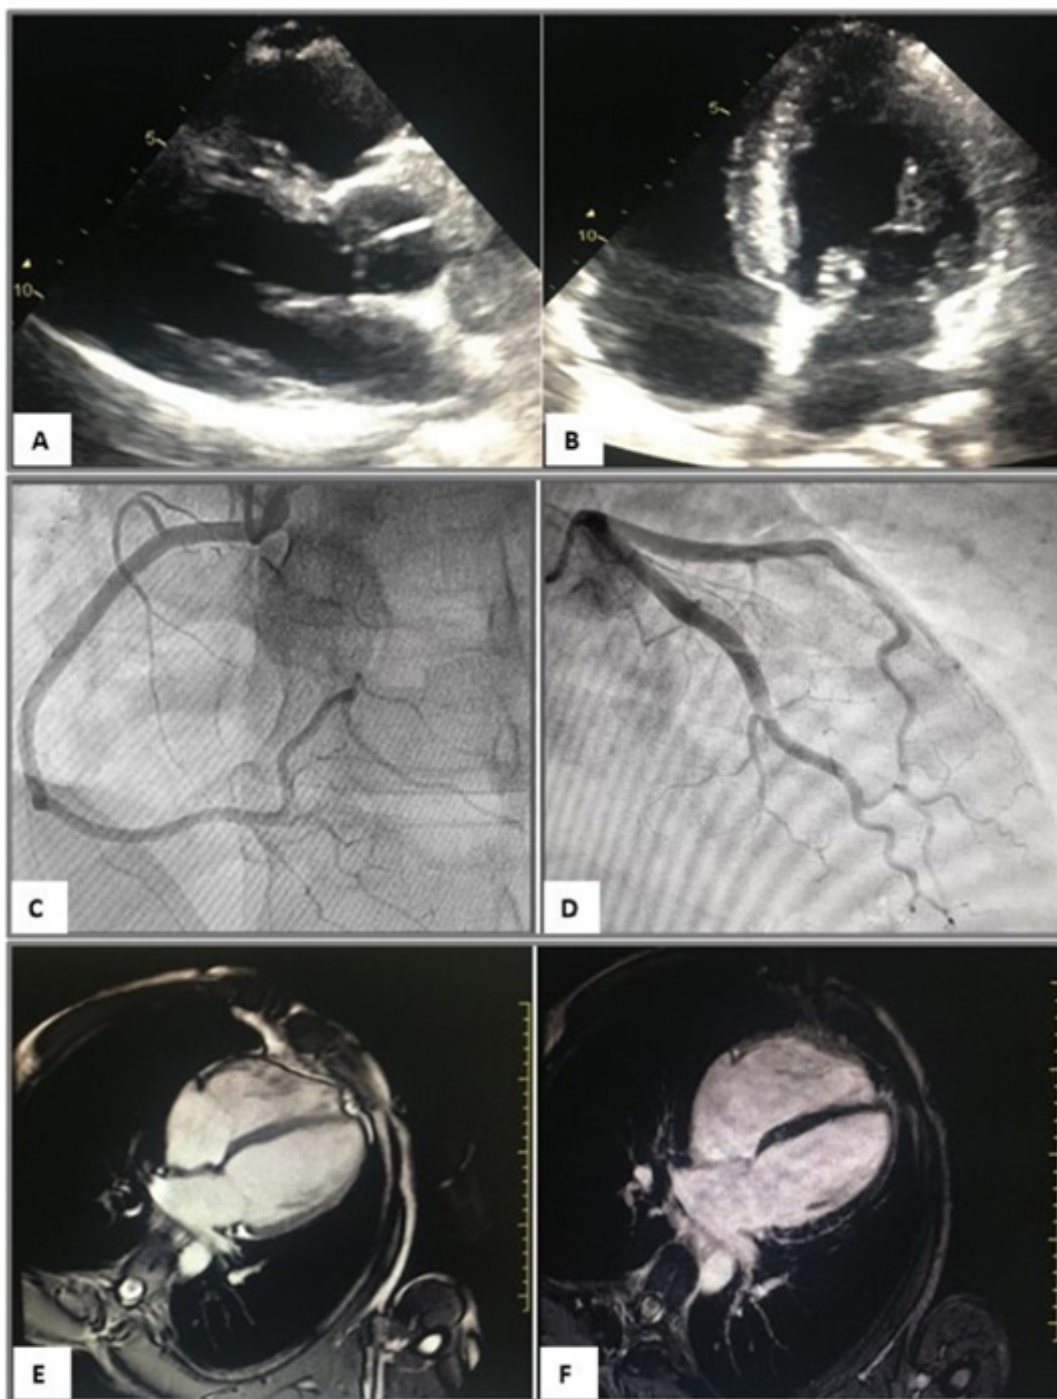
Transthoracic echocardiogram. A: parasternal long-axis view. B: apical 4-chamber view. Coronary angiography. C: Right coronary artery. D: Left coronary artery. Cardiac magnetic resonance imaging. E: cine imaging (SSFP): 4-chamber view. F: late gadolinium enhancement sequences: 4-chamber view.
